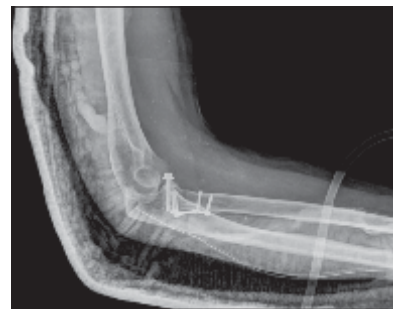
Post surgery X-ray of the elbow after open reduction and fixation with Titanium screws and plate with above elbow slab (Lateral view)
